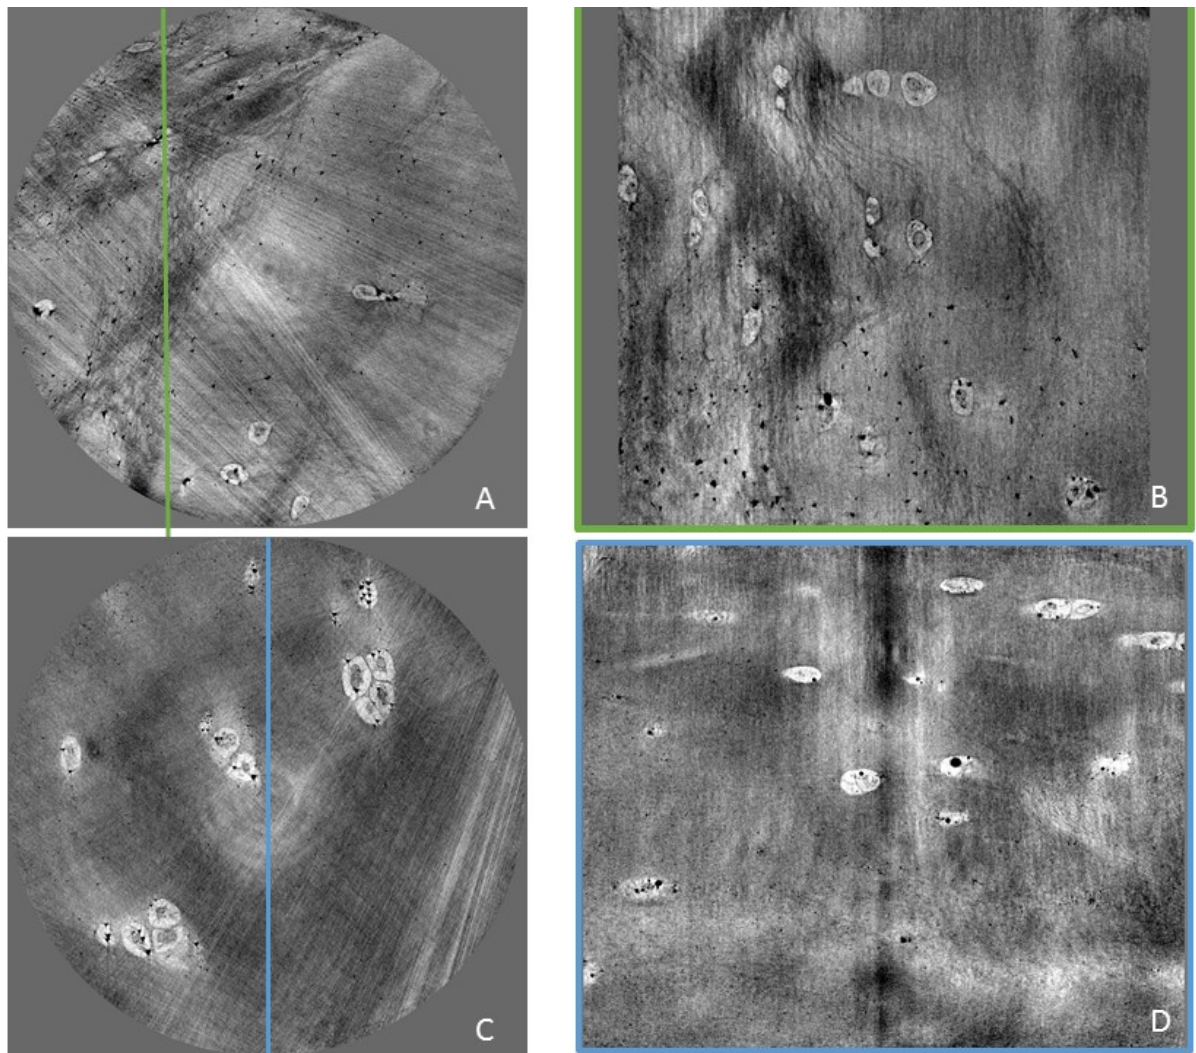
X-Ray holotomography images of the superficial-tangential zone in degenerated (top) and non-degenerated (bottom) cartilage. Left: axial view of the 3D reconstructed volume; right: sagittal view along the line in the axial view
